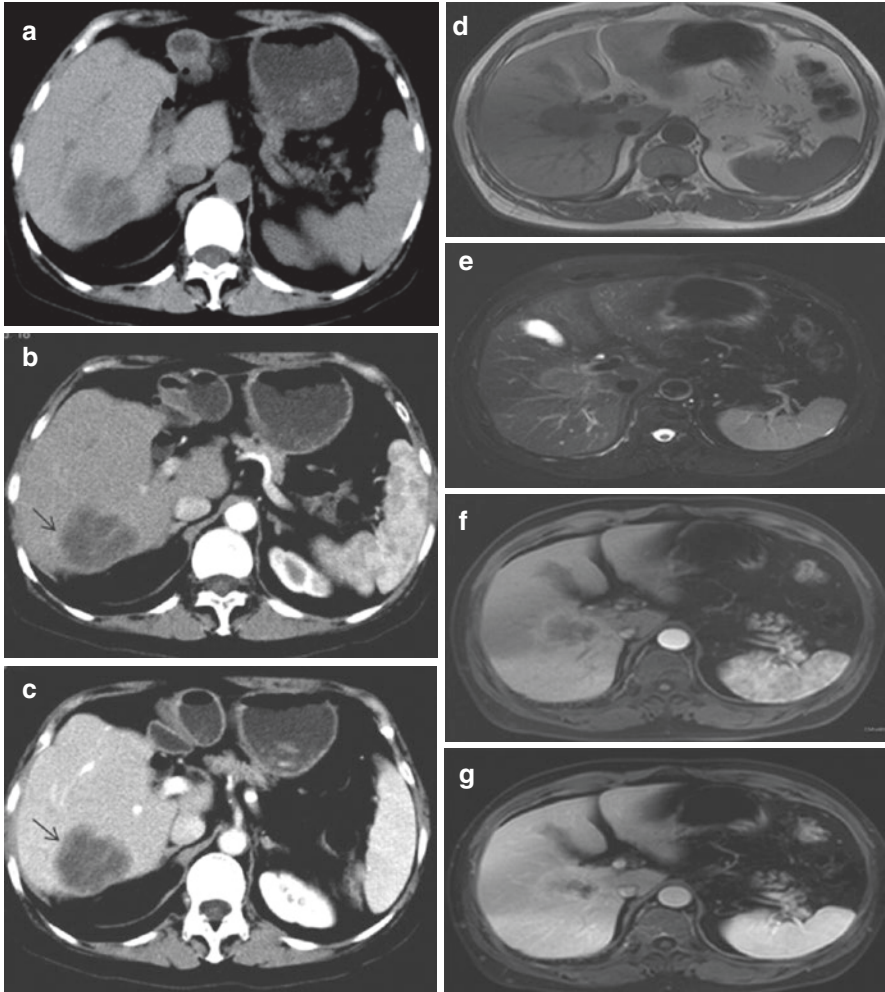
CompuRadiographic features of intrahepatic cholangiocarcinoma: (a–c) Computed tomography showing a low-density mass with a regular and distinct boundary on arterial (b) and portal venous phases (c). (d–g) Magnetic resonance imaging showing a mass low signal on T1-W1 (d) and a heterogeneous high signal on T2-W1 (e) with a regular and distinct boundary. The same features are present on the enhanced T1-W1, with a sharp ring-like enhancement, during the arterial (f) and portal venous phases (g). (From Jiang et al. [38], by permission of Oxford University Press)
